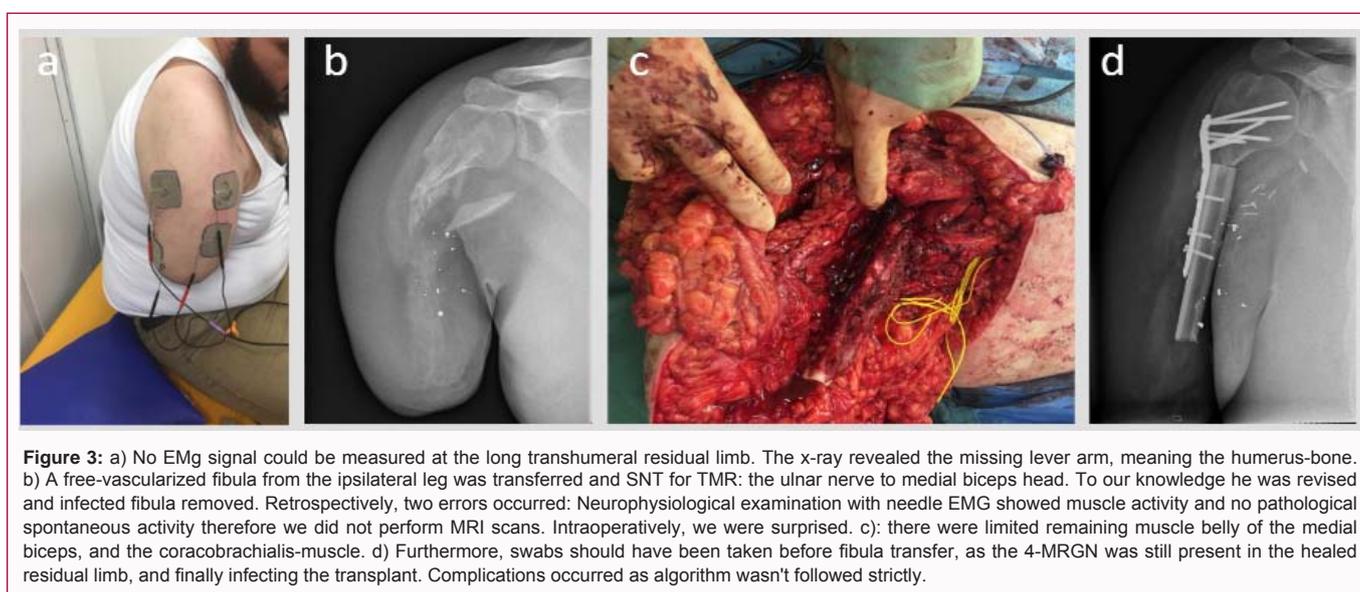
a) No EMg signal could be measured at the long transhumeral residual limb. The x-ray revealed the missing lever arm, meaning the humerus-bone. b) A free-vascularized fibula from the ipsilateral leg was transferred and SNT for TMR: the ulnar nerve to medial biceps head. To our knowledge he was revised and infected fibula removed. Retrospectively, two errors occurred: Neurophysiological examination with needle EMG showed muscle activity and no pathological spontaneous activity therefore we did not perform MRI scans. Intraoperatively, we were surprised. c): there were limited remaining muscle belly of the medial biceps, and the coracobrachialis-muscle. d) Furthermore, swabs should have been taken before fibula transfer, as the 4-MRGN was still present in the healed residual limb, and finally infecting the transplant. Complications occurred as algorithm wasn't followed strictly.
